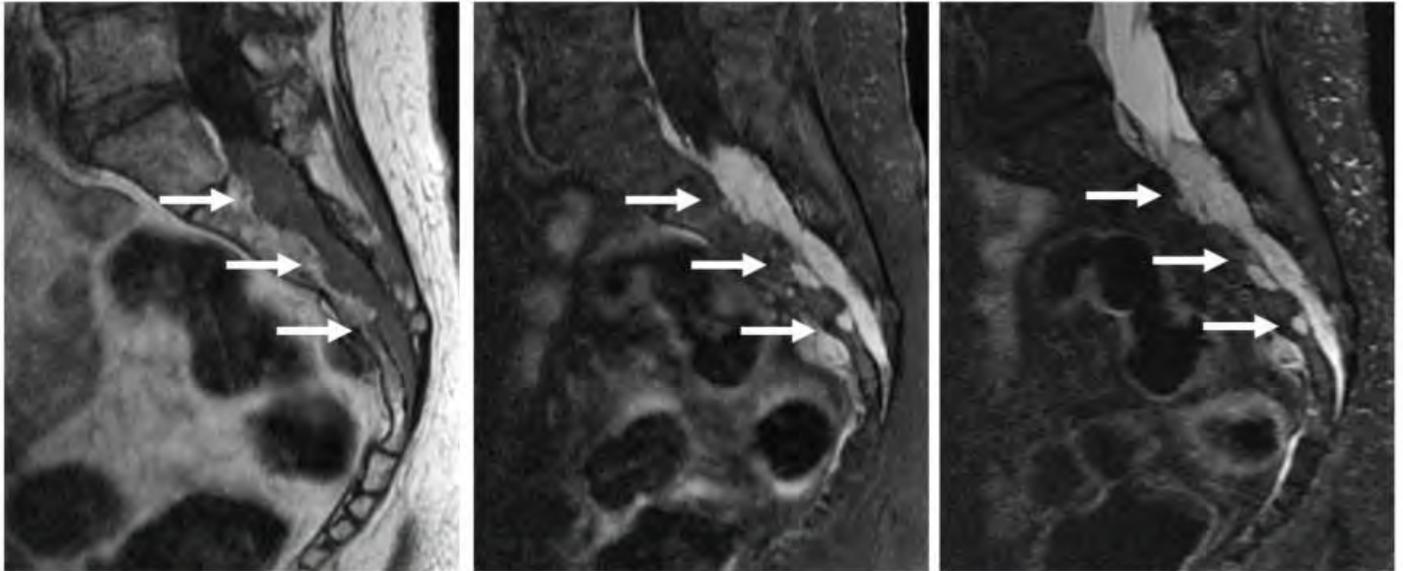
Selected T1-weighted, T1-weighted with fat saturation and contrast, and FIR images. There is a lobulated intradural avidly enhancing mass filling the sacral spinal canal and extending through the anterior sacral foramina.
